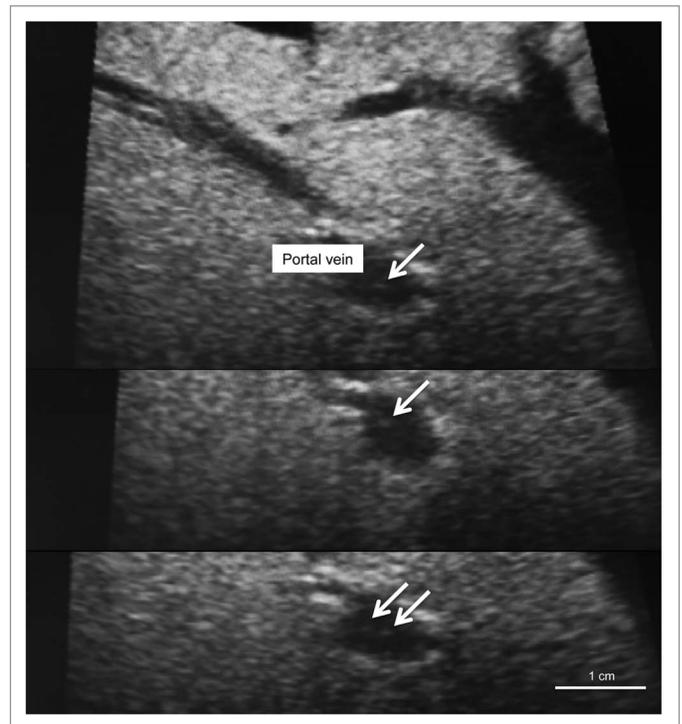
Intraoperative ultrasonographic (US) image for a patient who received islet autotransplantation. The transplanted islets appear as hyperechoic clusters in the portal vein. This is a modified version of a figure from a previous study.⁷⁶
